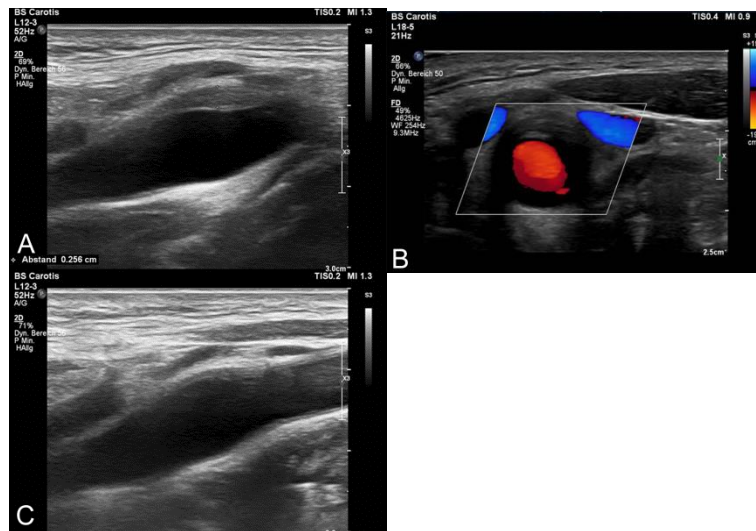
A 28-year old male patient presented with progressive pain during the last two weeks located at the region of the right carotid bifurcation. The pain did not decrease to a course of analgesic drug therapy with paracetamol. Systemic inflammatory markers were normal (CRP 4.3mg/L, ESR 4mm/1h, leucocyte 5.9g/L). Based on the clinical presentation and the results on standard ultrasound imaging the diagnosis of transient perivascular inflammation of the carotid artery (TIPIC) syndrome was made. B-mode ultrasound imaging using a 18-5MHz linear probe revealed a perivascular hypoechoic thickening with an onionskin like appearance at the carotid artery bifurcation in the longitudinal view (A) and in the cross-section view (B) without stenosis on colour Doppler ultrasound. After a course of non-steroidal anti-inflammatory drug of 7 days the patient was asymptomatic. A follow-up ultrasound study after 3 weeks of the carotid artery revealed a clear resolution of the perivascular lesion (C).
